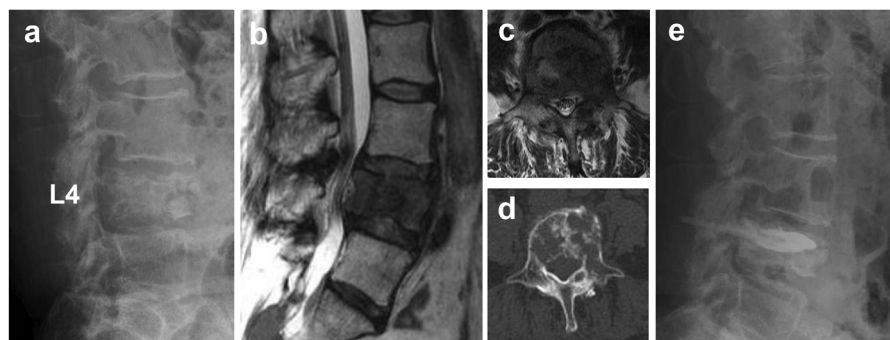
Balloon kyphoplasty (BKP) for MST. (a) Lateral X-ray image of a 57-year-old female with L4 metastasis from breast cancer. (b) Sagittal T2-weighted MRI image. (c) Axial T2-weighted MRI image. (d) Axial CT image showing intact posterior wall of the spinal canal. (e) Post-BKP lateral X-ray image.
